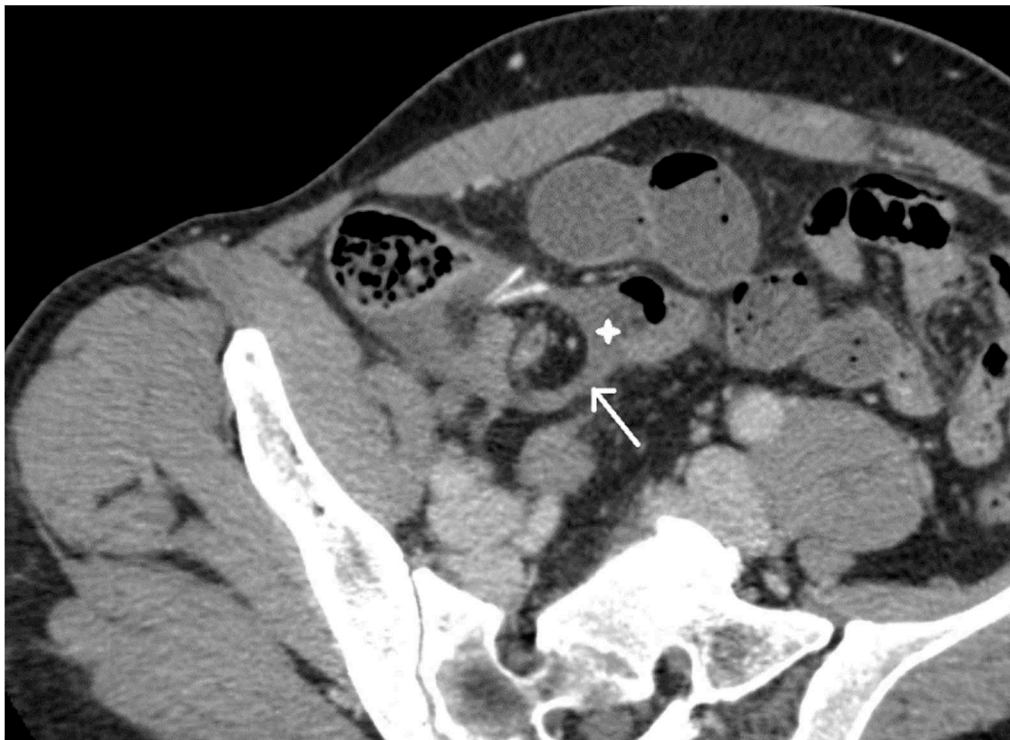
CT scan: Pedunculated base of the MD (arrow) and MD (star).
